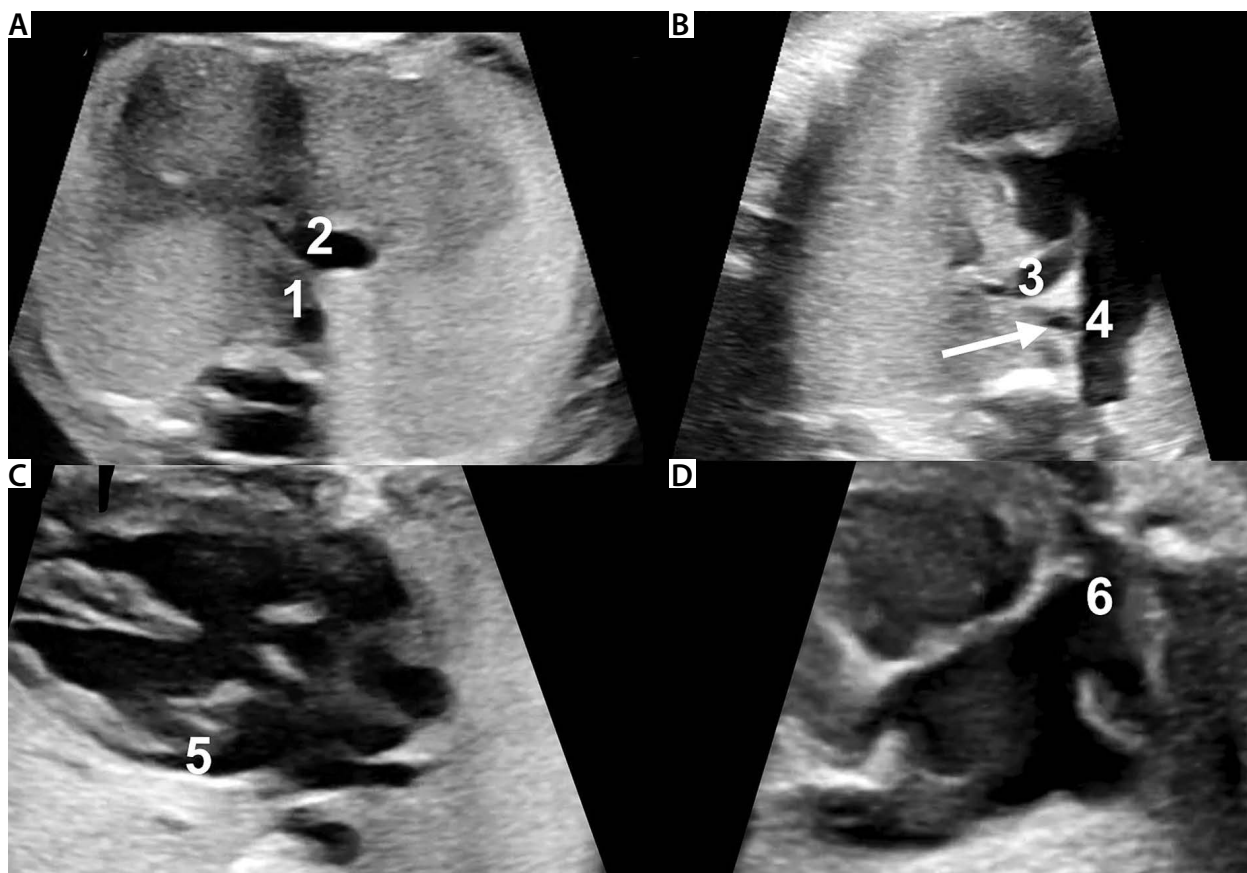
Fetal echocardiography at 31 weeks of gestation: A – an upper abdominal view: ipsilateral location of the descending aorta and the inferior vena cava; B – the right ventricular outflow tract: aortopulmonary window and the right-sided aortic arch are visualised; C – a five-chamber view: the left atrial appendage is seen; D – a venous systemic return view: the right atrial appendage is observed
